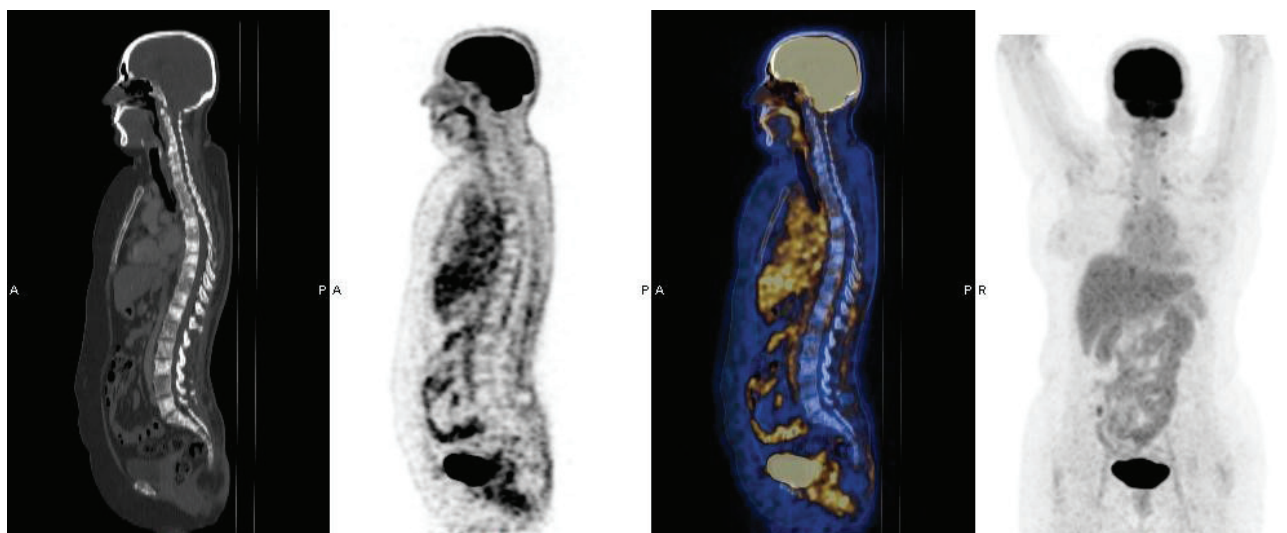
F-18 FDG PET-CT scan after 2 years of treatment showed no metabolically active bony lesion in the entire imaged skeleton, suggestive of complete treatment response.
